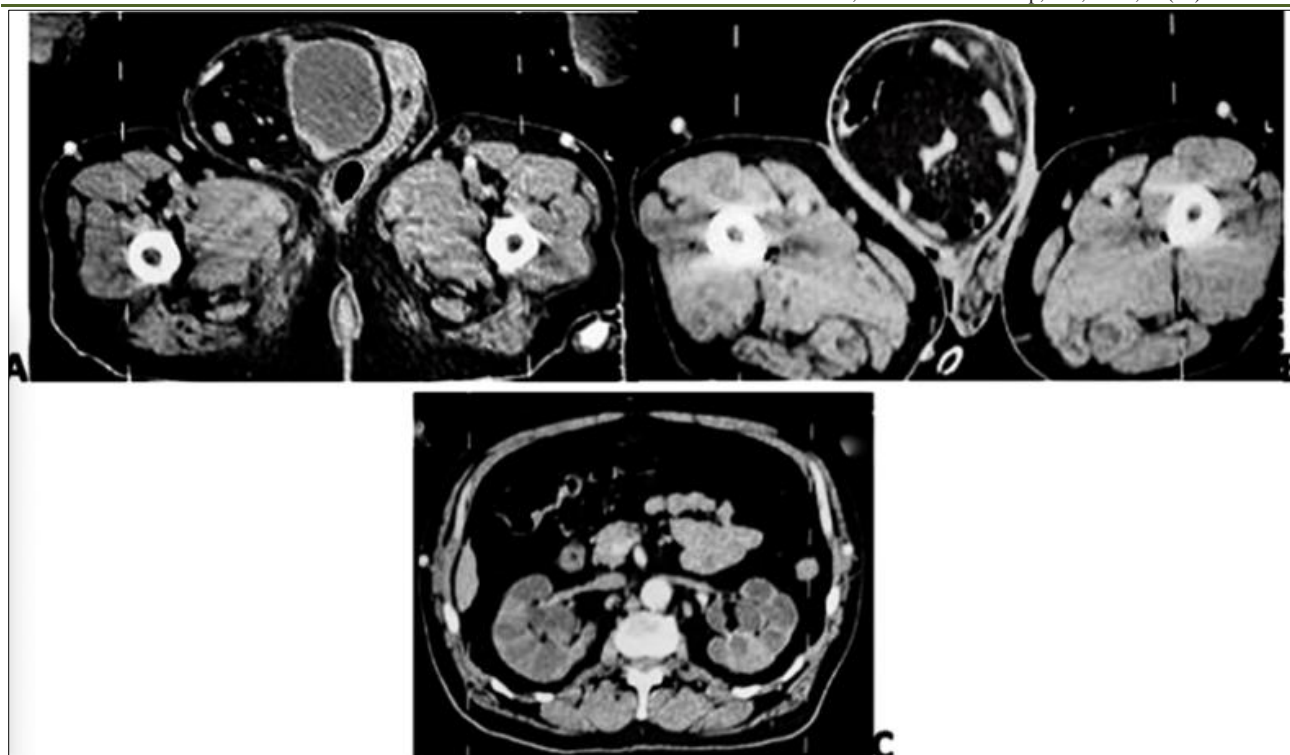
(A, B, C): Abdominal CT scan in axial section showing: right inguinal hernia sac measuring 15.6 x 5 mm, through a 47 mm parietal defect, containing intestinal and omental contents, and with partial incarceration of the bladder and right ureteral orifice with major bilateral dilation of the pyelocaliceal cavities and the entire ureter, with renal cortical thinning, pale nephrogram, and delayed secretion and excretion within normal timeframes
